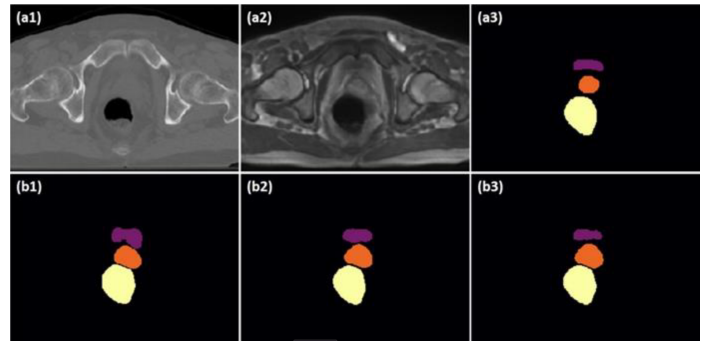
Comparison between original and synthetic scans generated by the method proposed by [Lei et al. \[2020a\]](#), and segmentations: (a1) CT image; (a2) synthetic MRI; (a3) manual segmentation of bladder, prostate, and rectum. (b1) segmentation by DSU-net; (b2) segmentation by DAU-net trained on CT data; (b3) segmentation by DAU-net trained on synthetic MRI data.
